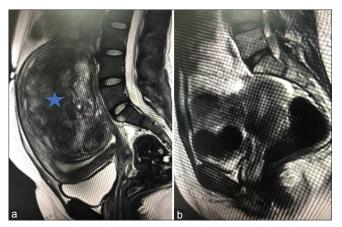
(a) T2-weighted images of the patient with a large uterine fibroid (star) reaching the umbilicus, causing menorrhagia and pressure symptoms. (b) Two-year postuterine artery embolization with significant reduction in the size of the fibroid
